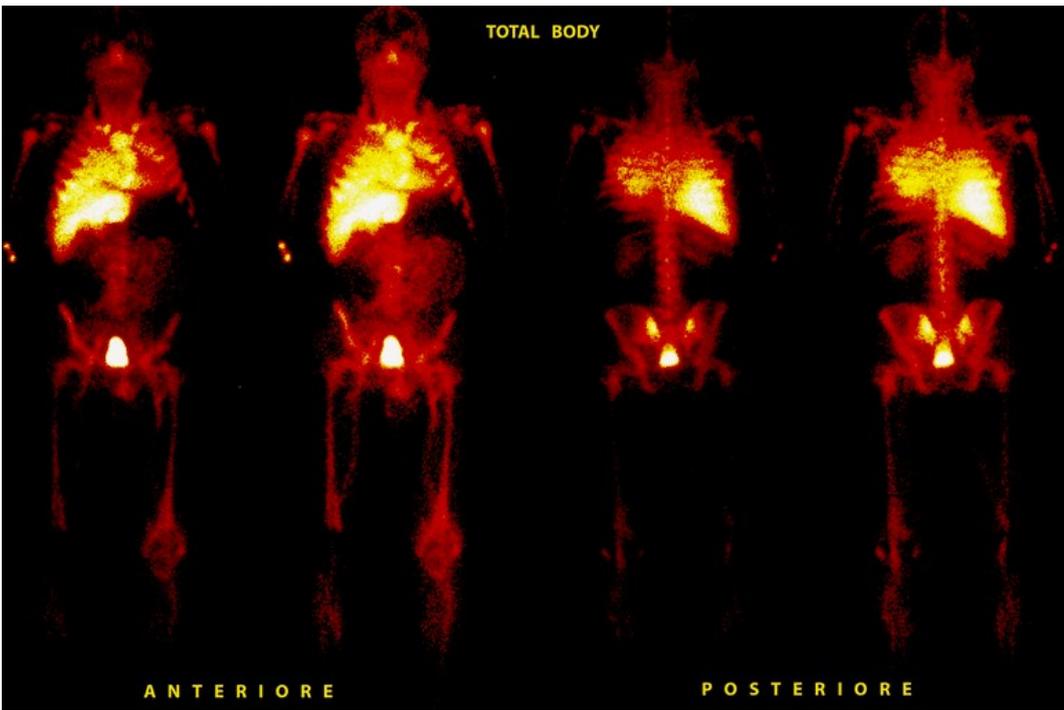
Lung scintigraphy result
